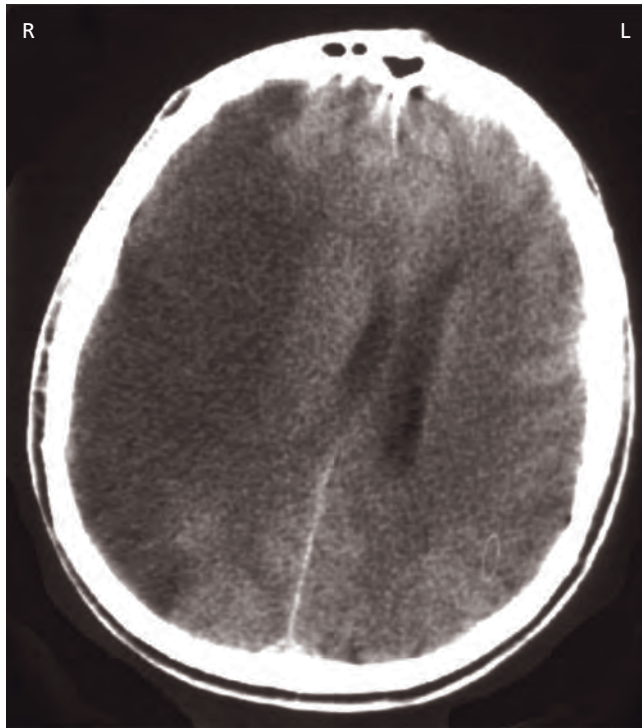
Cytotoxic oedema with brain swelling following right MCA occlusion (unenhanced CT).
